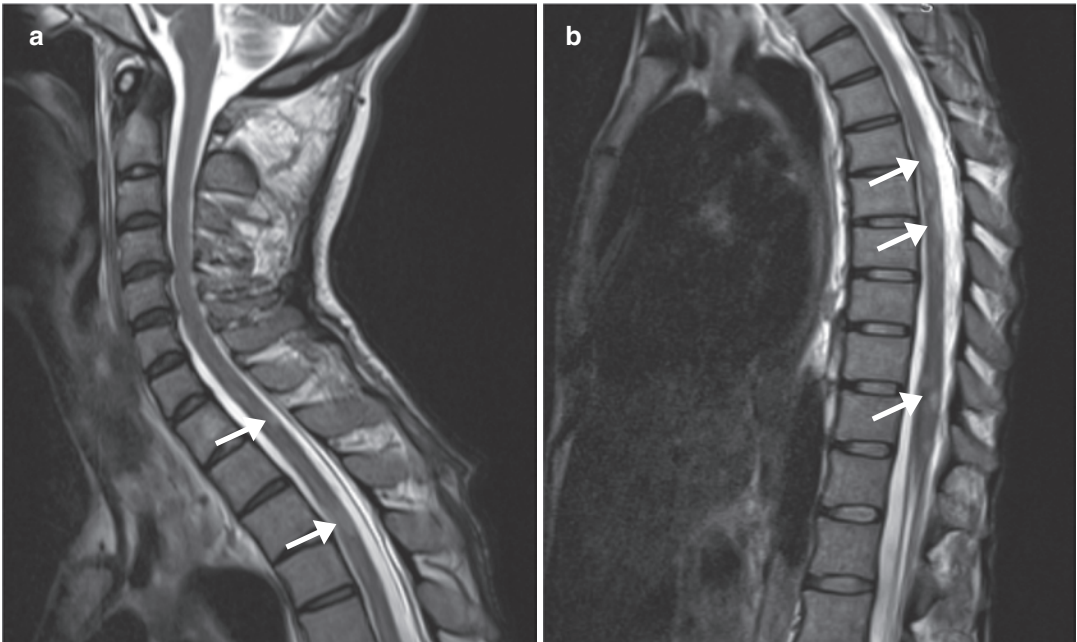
Spinal tuberculous myelitis. (a and b) Sagittal T2-W MR images show a slight diffuse spinal cord swelling containing multiple focal demyelinating lesions
